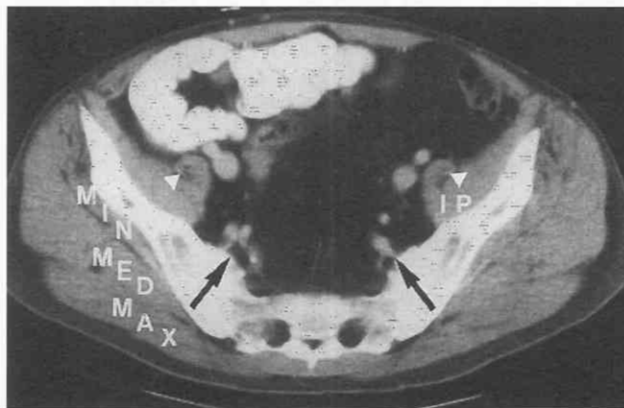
Normal anatomy. CT scan at the inferior sacroiliac joints shows the external iliac arteries and veins medial to the iliopsoas muscles (IP), which enclose the femoral nerves (arrowheads) and posterior dividing branches of the internal iliac arteries and veins (arrows). The gluteus minimus (MIN), gluteus medius (MED), and gluteus maximus (MAX) muscles compose the buttocks.
